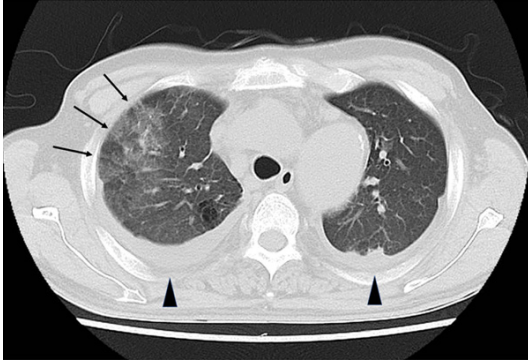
Lung CT shows diffuse ground-glass opacification, predominantly in the upper region of the right lung (arrows), associated with pleural effusion in both lungs (arrow heads). No infectious or autoimmune cause was identified.
